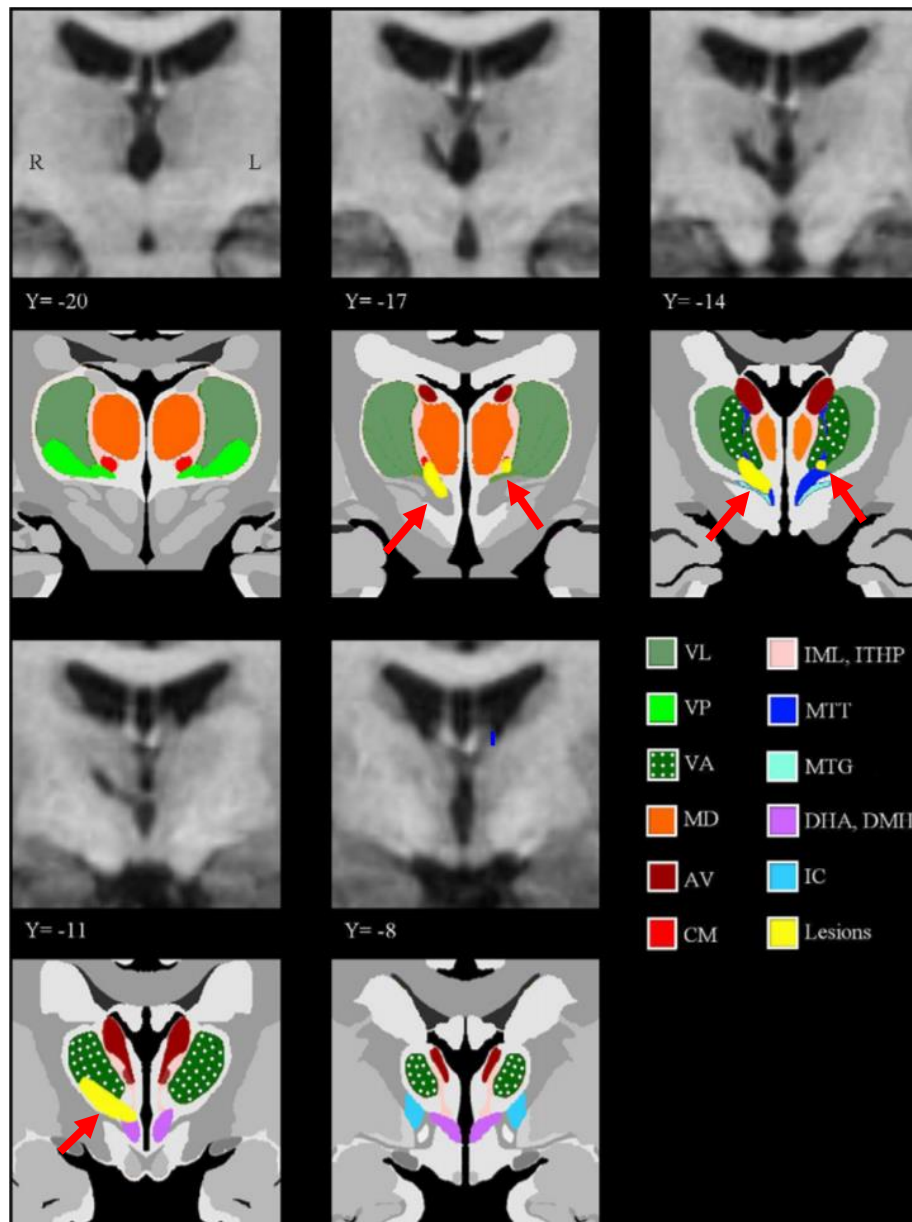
T1-weighted coronal slices (1 mm thick) through the thalamus (top row and third row down) with corresponding atlas plates upon which the lesion has been superimposed in yellow. Red arrows point to the lesion site of interest. Note the MTT has been shown here in blue. VL = ventrolateral thalamic nuclei; VP = ventroposterior thalamic nuclei; VA = ventroanterior thalamic nuclei; MD = mediodorsal thalamic nuclei; AV = anteroventral thalamic nuclei; CM = centromedian thalamic nuclei; IML = internal medullary lamina of thalamus; ITHP = inferior thalamic peduncle; MTT = mamillothalamic tract; MTG = mamillo tegmental tract; DHA = dorsal hypothalamic area; DMH = dorsomedial hypothalamic nucleus; IC = internal capsule. Adapted from Carlesimo et al., (2007).
